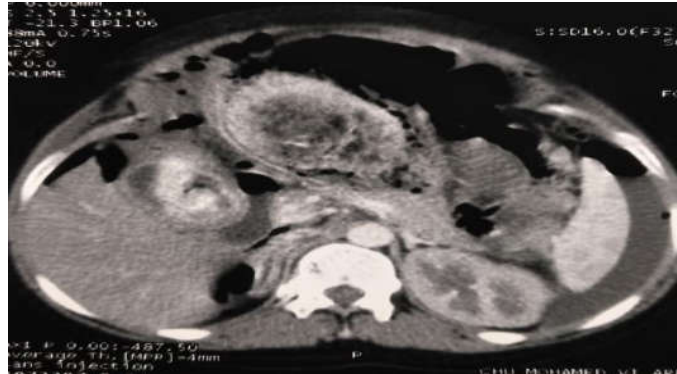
CT scan with a large intragastric mass, with pneumoperitoneum and peritoneal thickening
